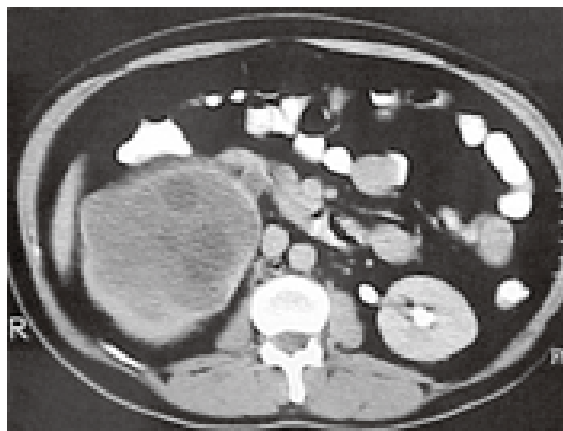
Renal hydatid disease. Enhanced axial CT image shows a hypodense mass involving the right kidney. Daughter cysts have a slightly lower density than the mother cyst.
